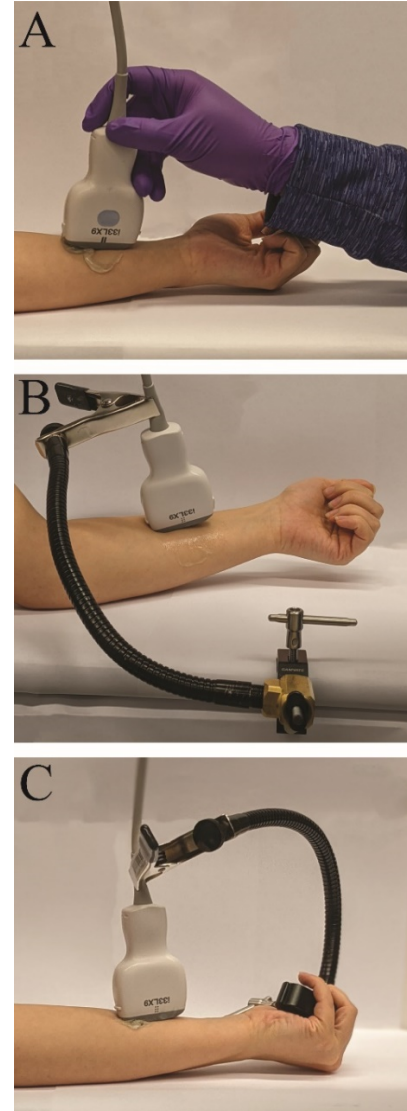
IMAGING THE FOREARM WITH THE ULTRASOUND PROBE (A) HELD BY HAND, (B) HELD IN PLACE BY A HOLDER ATTACHED TO THE TABLE, (C) HELD BY THE PROPOSED PROBE HOLDER
